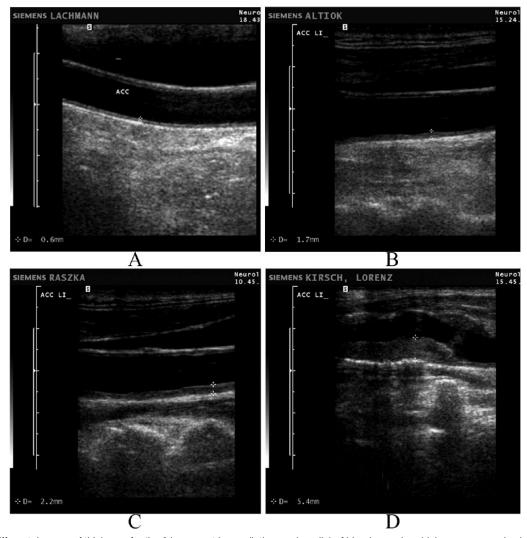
(A-D) Different degrees of thickness for the 2 innermost layers (intima and media) of blood vessels, which are measured using B-mode ultrasonography.
